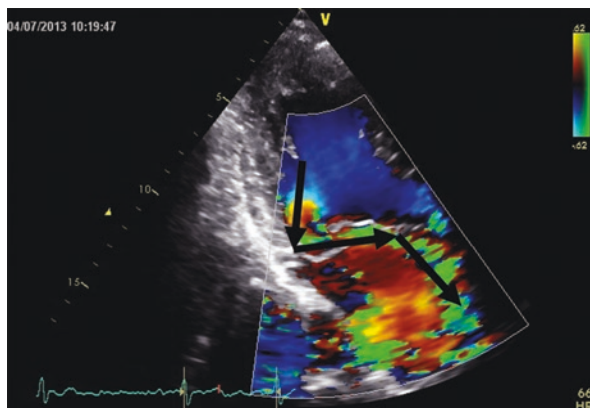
Two-dimensional transthoracic apical long-axis view demonstrating severe mitral regurgitation in patient with flail mural (posterior) mitral valve leaflet with Coanda effect of the jet. There is also extreme flow constriction invalidating the PISA method, as demonstrated by the black arrows showing change in direction in between the three components of the jet
